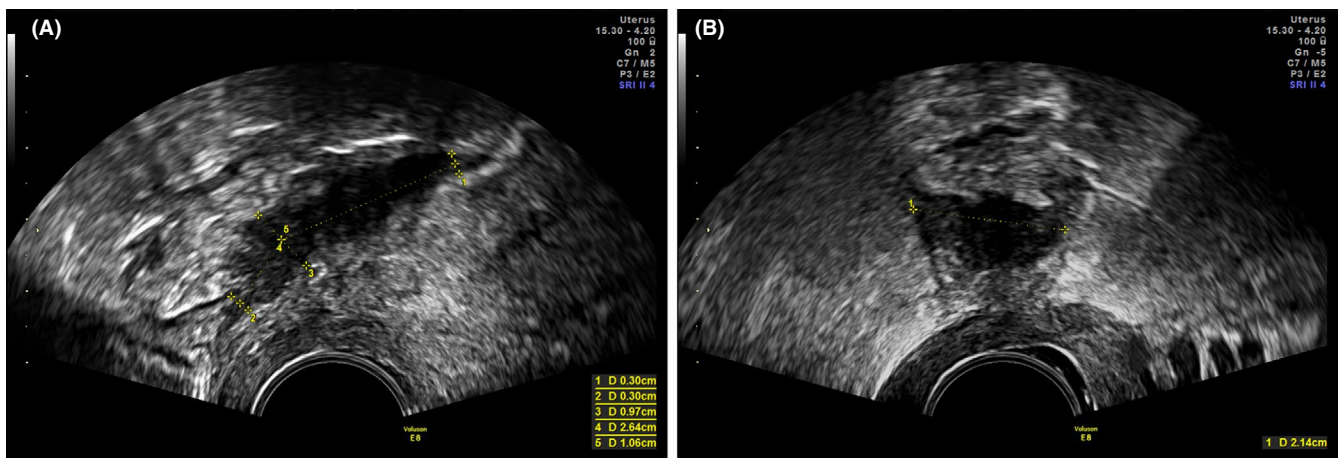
Measurement of a rectosigmoid nodule by transvaginal sonography. A, 1 and 2: Limits for measurement of length, where the muscular layer ≥ 3 mm. 3: infiltration depth. 4 + 5: measurement of length. B, 1: measurement of width [Color figure can be viewed at wileyonlinelibrary.com]
